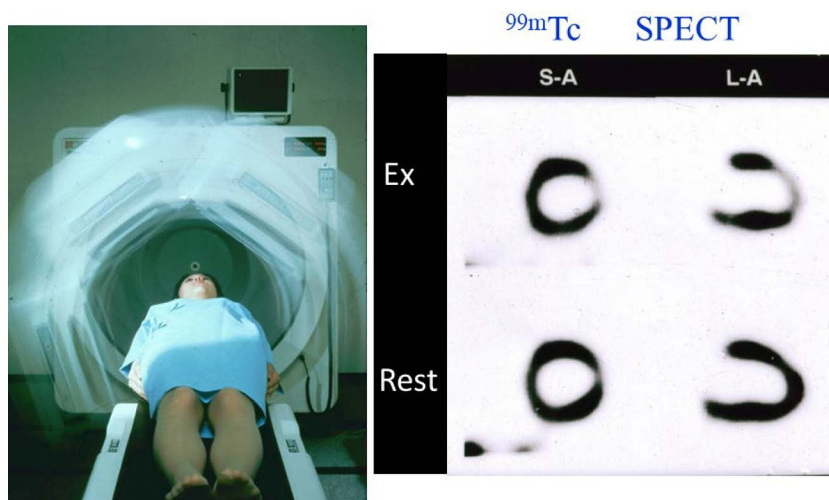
Clinical use of SPECT (left) prevailed in 1980's making short axis(S-A) and long axis(L-A) tomography of myocardial perfusion images in excise (Ex) and rest conditions (right) (Color online).
